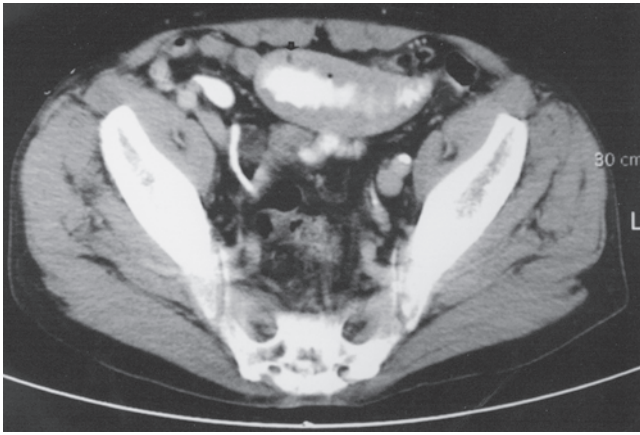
Thickening of the bowel wall on abdominal CT scan characteristic of lymphoma.
